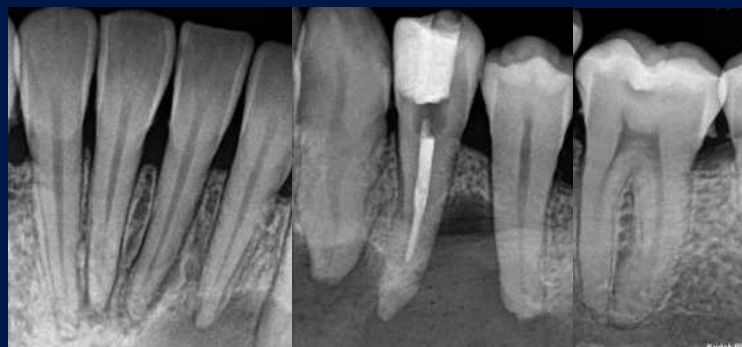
Initial radiographs of teeth 36 to 41
